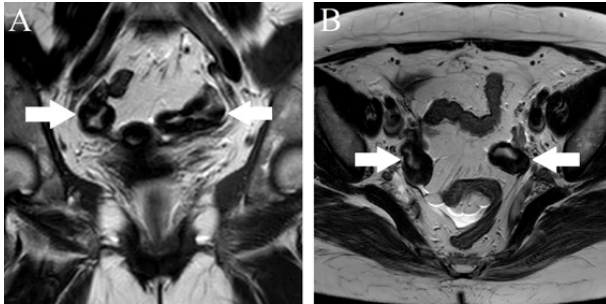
MRI in T2 weighted sequence (A, coronal image; B, axial image) demonstrate increased ovarian size, fibrous thickening with its trapping follicles (white arrows).
